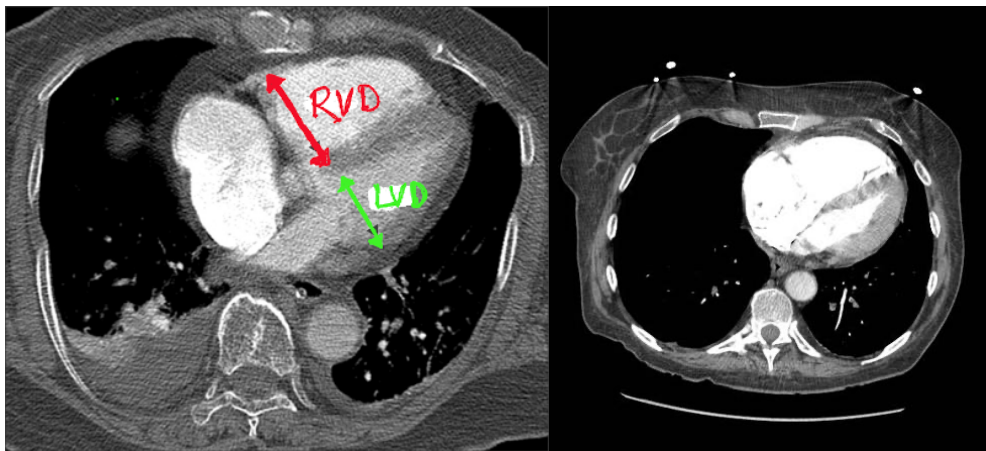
(Left Figure) CT where we can observe a healthy heart with both ventricles with relative common dimensions. (Right Figure) CT where we can notice how the upper left part (right ventricle) is much larger than the lower right part (left ventricle). This patient is having a severe PE causing significant right heart strain.
